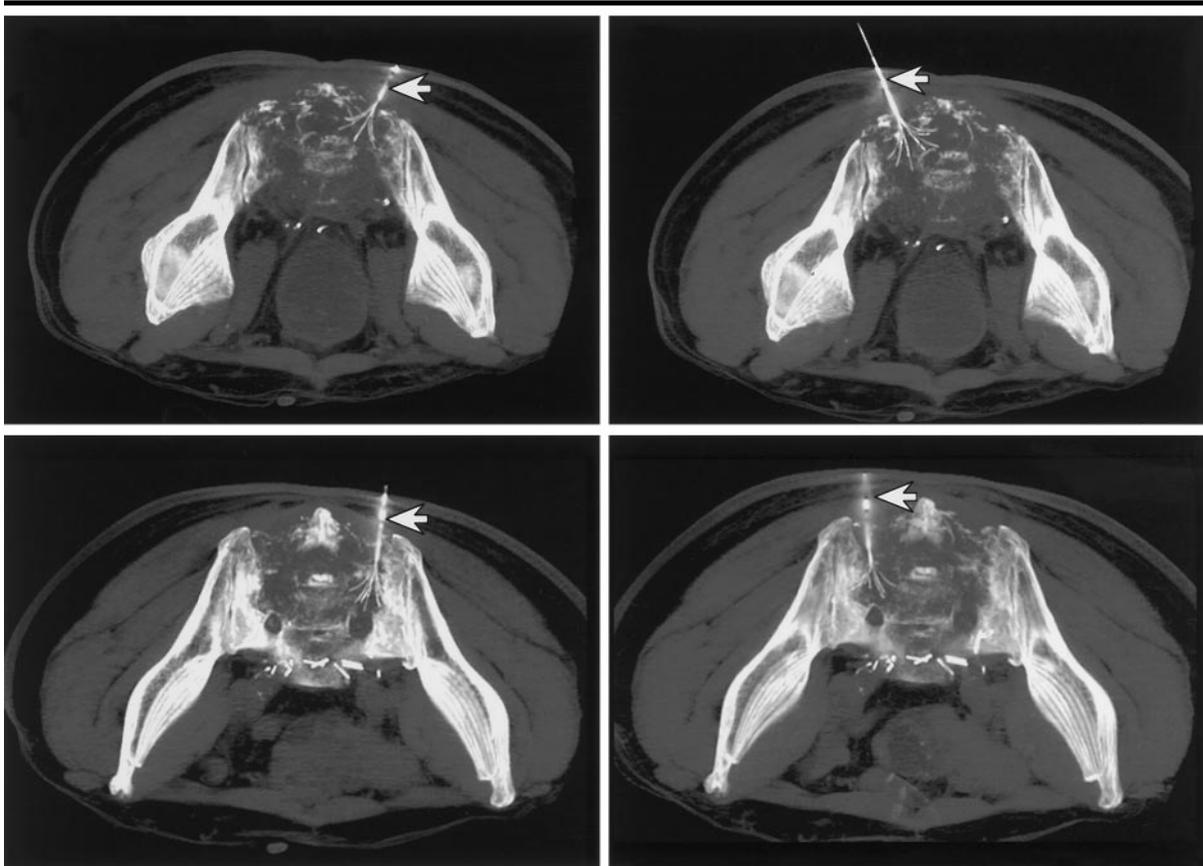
Patient 4. Transverse three-dimensional volume CT images obtained at the level of the sacrum with the patient prone show four of 14 percutaneously placed RF electrode deployments (arrows) in an osseous and soft-tissue colorectal carcinoma metastatic lesion diffusely involving the sacrum. Before RF ablation, the average pain score was 8. At 4, 6, and 8 weeks after ablation, the average pain score was 3, 2, and 1, respectively. At 6 months after ablation, the reported average pain score was 0.
